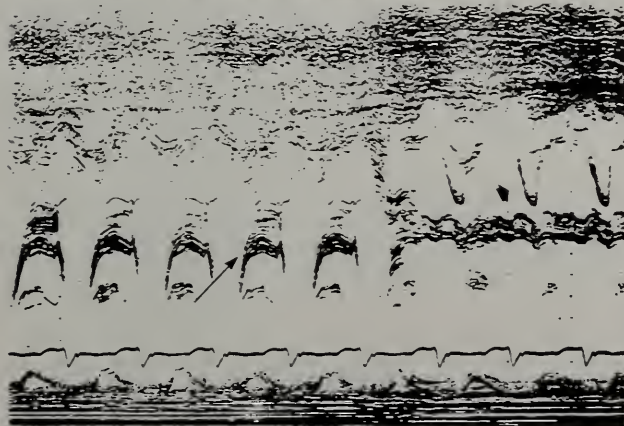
Echocardiogram demonstrating right ventricular enlargement with a normal appearing anterior mitral valve leaflet (thick arrow) and the multiple echo pattern from the tricuspid valve (thin arrow).
